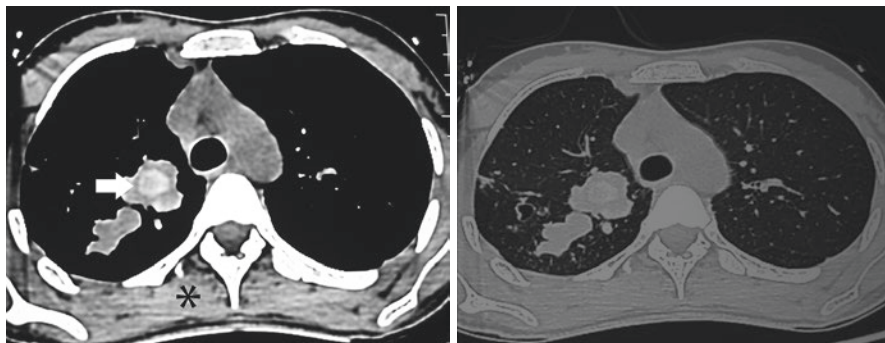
High-resolution computed tomography of the thorax (mediastinal window, right panel) showing high-attenuation mucus (arrow) within a bronchocele (mucus filled bronchiectatic cavity). The mucus is visually denser than the paraspinal skeletal muscle (asterisk). The corresponding lung window is shown in the left panel
